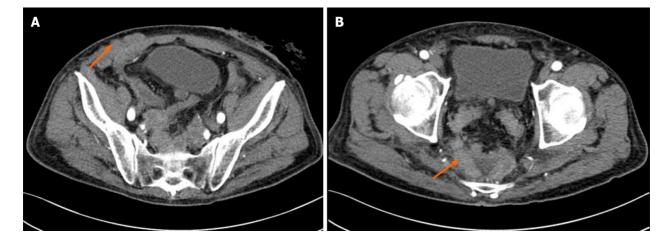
Contrast-enhanced computed tomography imaging scans 1 mo after surgery. A: Computed tomography imaging showed that there were multiple nodules in the lower abdomen, which was consistent with our physical examination; B: There were many new lesions in the pelvis (orange arrow) compared with Figure 2B.
